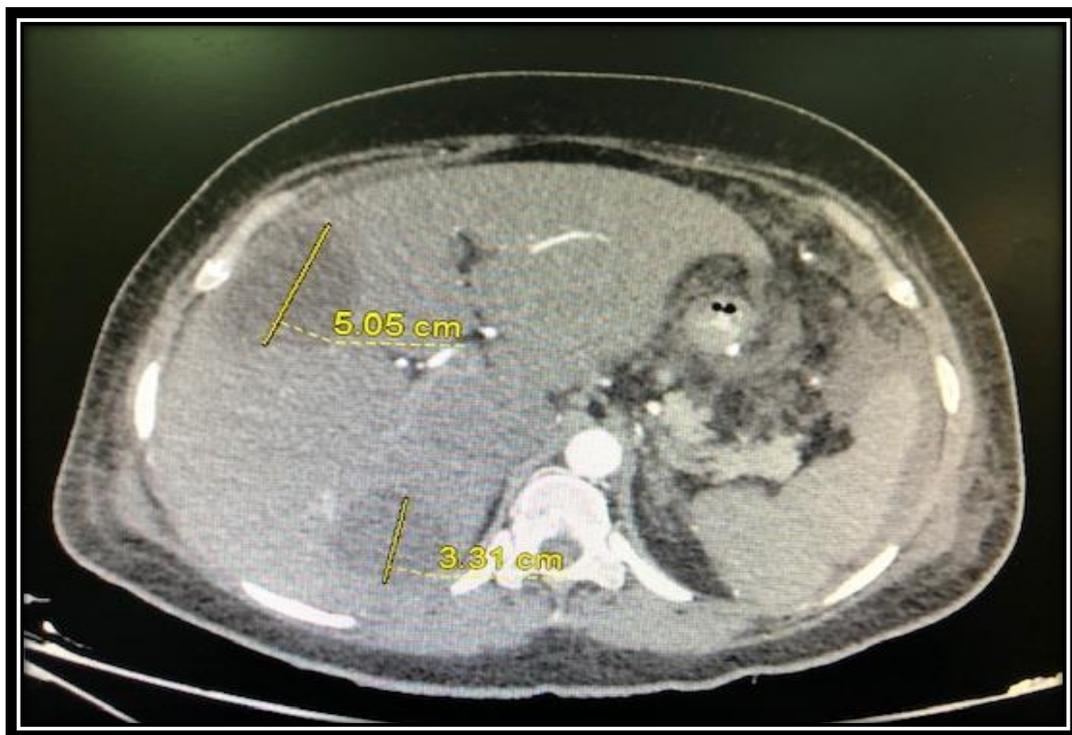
Abdominal CT with contrast shows that free fluid is adjacent to the cyst which is compatible with ruptured hydatid cyst with free peritoneal fluids.
